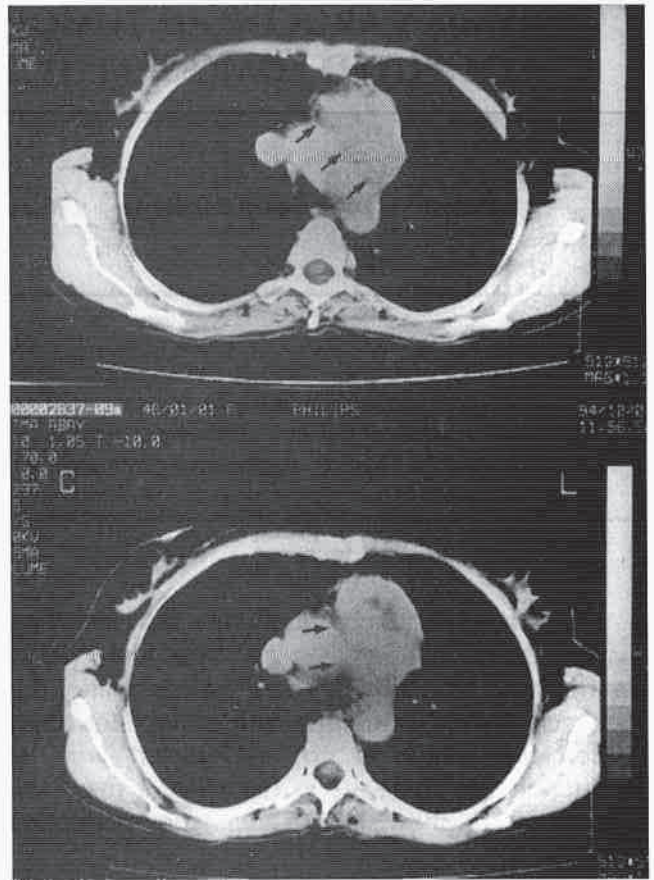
CT demonstrates the mass lesion (arrows) located anterior aspect of aortic arch.
